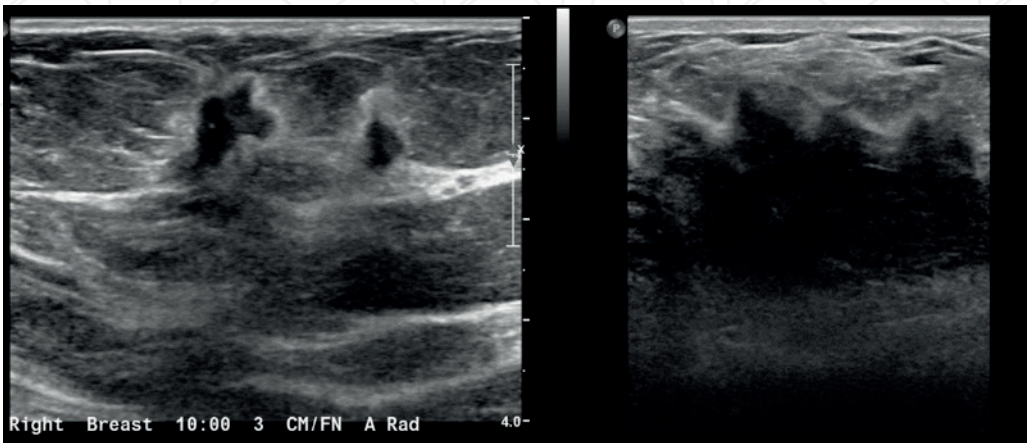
Margin assessment. Transverse ultrasound of the right breast demonstrates an irregular mass with angular margins. Some or all of the margins has sharp corners, often forming acute angles.
